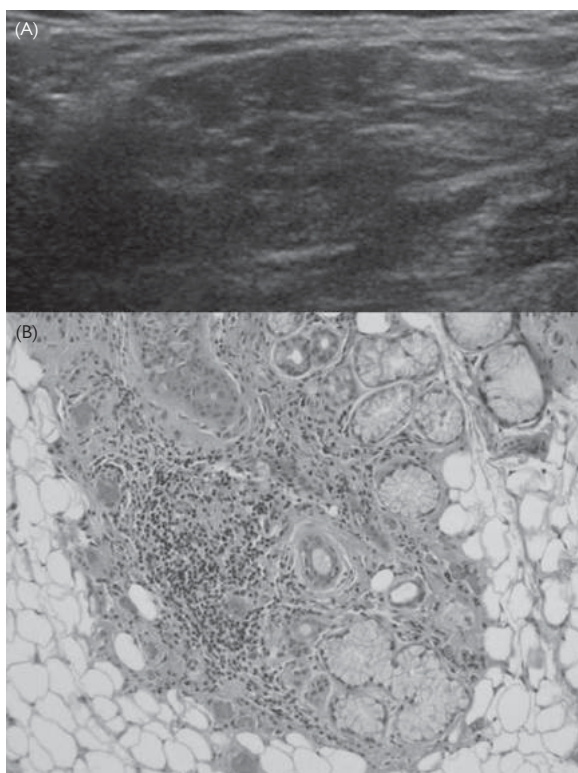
(A) Ultrasound of left submandibular gland shows heterogeneous echotexture with multiple hypoechoic areas surrounded by hyperechoic bands. (B) Despite the presence of extensive atrophy and fat replacement, some lymphocytic foci are adjacent to normal appearing acini and ducts. This is important as such atrophic features can be accompanied by lymphocytic infiltration and even foci, in the context of a non-specific chronic sialadenitis.
